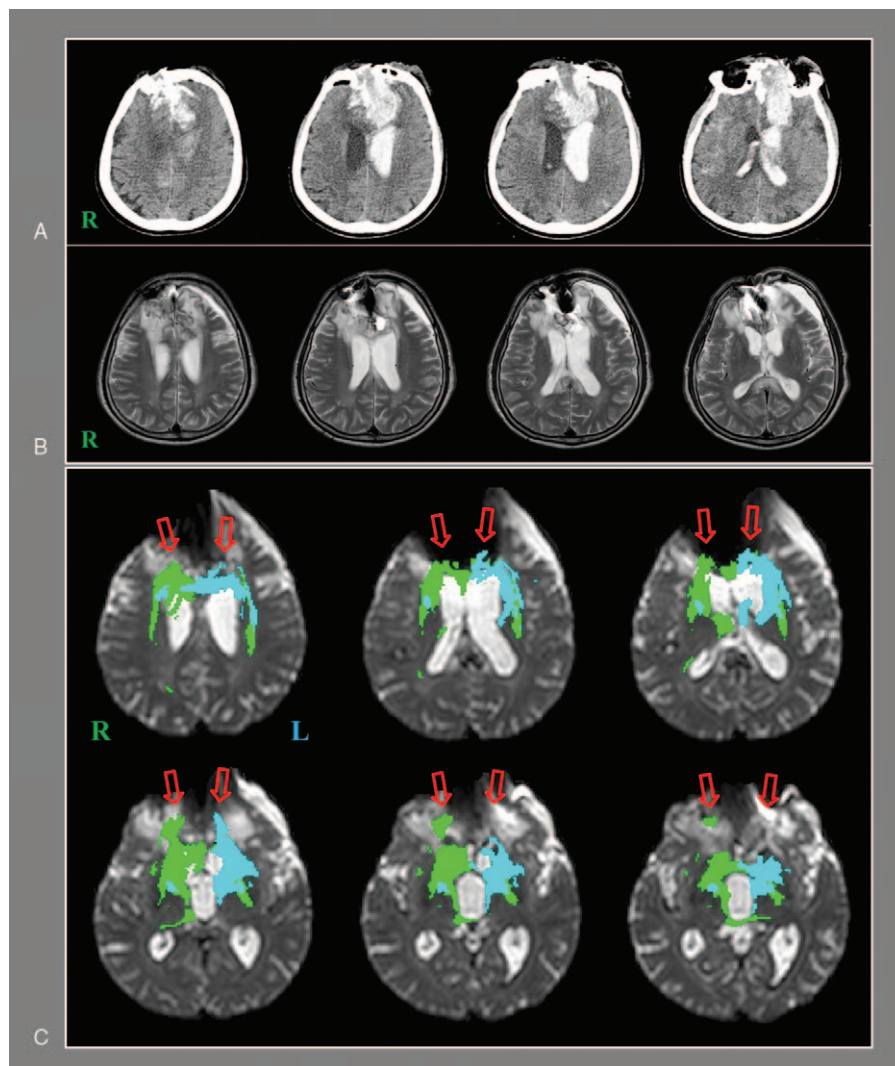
(A) Brain computed tomography images at onset show traumatic intracerebral hemorrhage in both frontal lobes and intraventricular hemorrhage. (B) T2-weighted brain MR images at 2 months after onset show leukomalactic lesions in both frontal lobes. (C) On 2-month diffusion tensor tractography, the neural connectivity of the caudate nucleus to the medial prefrontal cortex (PFC, Brodmann area [BA]: 10 and 12) and orbitofrontal cortex (BA 11 and 13) is decreased (arrows) in both hemispheres.
